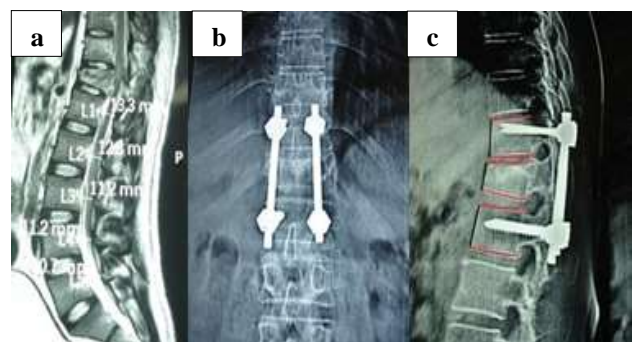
(a) MRI showing wedge compression of D12 compressing the cord, (b) and (c) immediate post-op.
